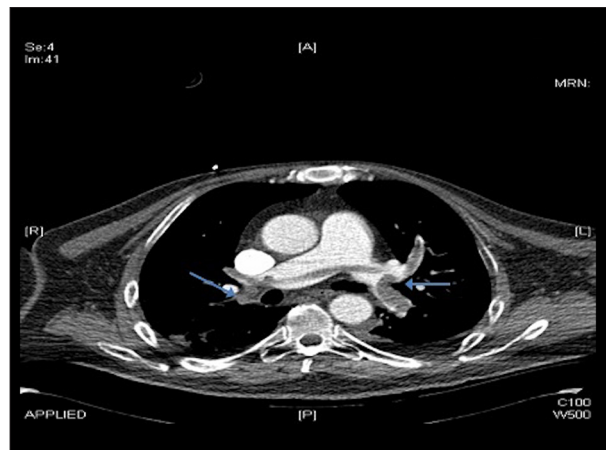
Computed tomography angiography showed both pulmonary arteries are occluded subtotally by a single, drawn-out embolus. Blue arrows indicate the bilateral pulmonary embolism.
